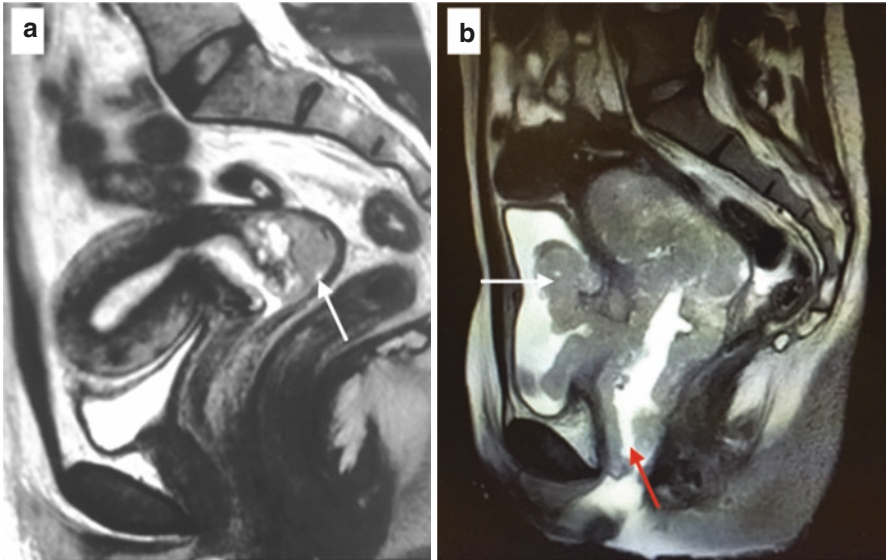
(a) Sagittal section of magnetic resonance imaging showing a stage Ib3 cervical cancer. (b) Magnetic resonance showing a locally advanced stage IVa cervical with extension to the bladder (white arrow) and external 1/3 of vagina (red arrow)
